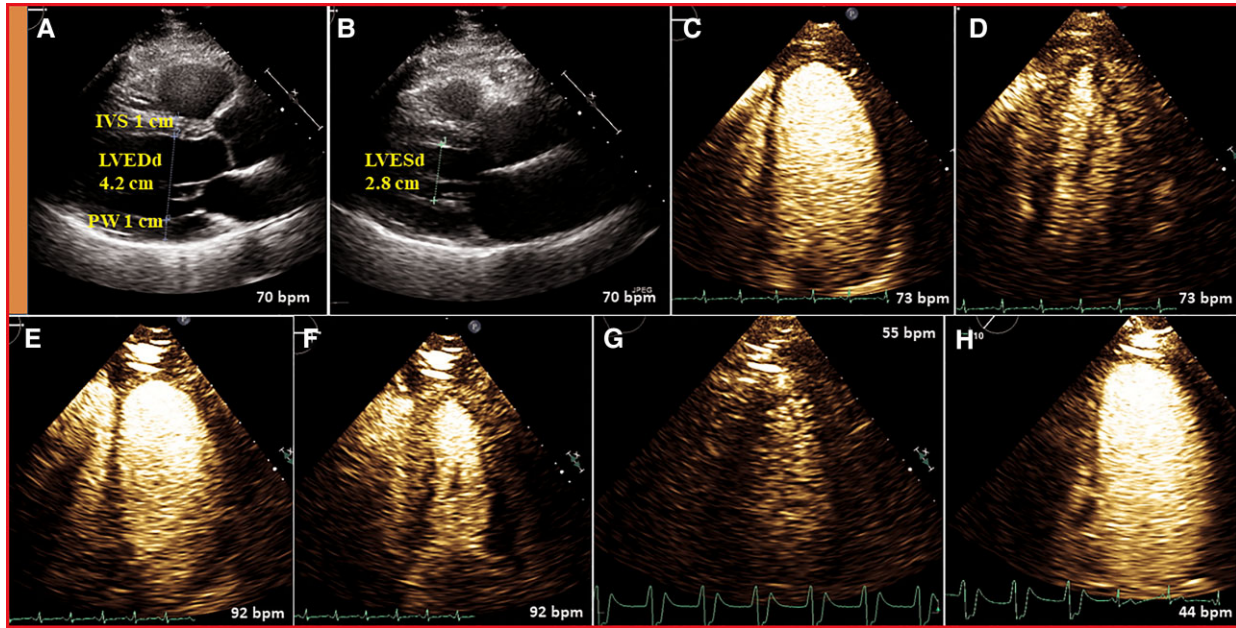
Resting and dobutamine stress echocardiography images (Case 5). (A, B) Parasternal long-axis views; (A) end diastole (interventricular septum 1 cm, left ventricular 4.2 cm and posterior wall 1 cm) and (B) end systole (left ventricular 2.8 cm). (C, D) Contrast-enhanced images showing apical four-chamber views at rest; (C) end diastole and (D) end systole, indicating a uniform reduction in left ventricular radial diameter and increase in myocardial thickness. (E–H) Dobutamine stress echocardiography images (Stage 3); (E) end diastole; (F) end systole with heart rate, 92 b.p.m.; (H) PSD, nodal rhythm with heart rate, 44 b.p.m.; and (G) subsequent restoration of sinus rhythm with heart rate, 55 b.p.m. HR, heart rate; IVS, inter-ventricular septum; LV, left ventricular; PW, posterior wall.
